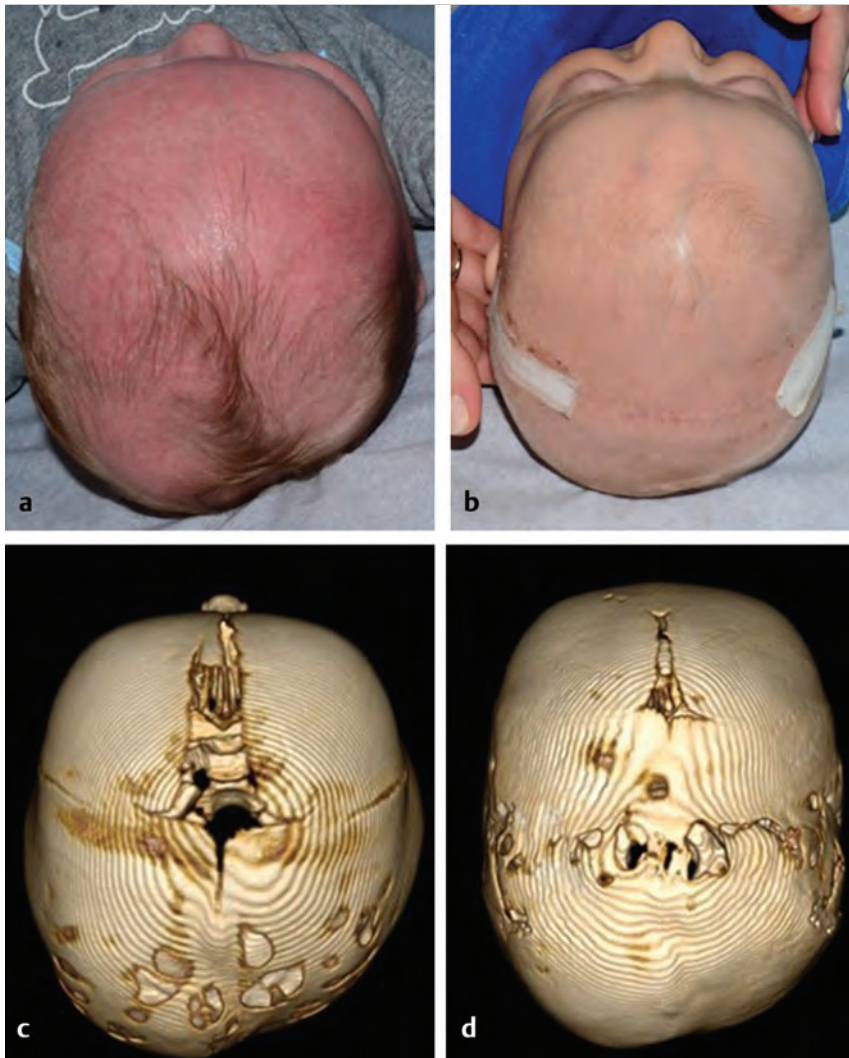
(a) Pre- and (b) postoperative photographs of a patient with Pfeiffer's syndrome, bicoronal craniosynostosis, and resulting brachycephaly, who underwent posterior vault distraction osteogenesis with (c) pre- and (d) postoperative 3D CT scans.
